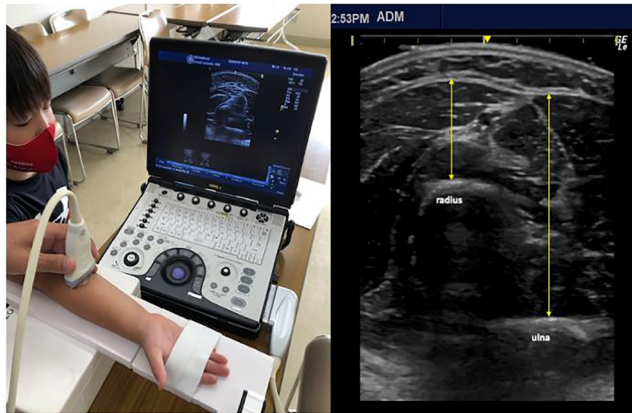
The left side of the figure is the measurement setup used in this study. An expanded polystyrene board was placed between the forearm and the table, and the four fingers, except for the thumb, were fixed to the board with elastic bands. The right side of the figure is a typical ultrasound image
